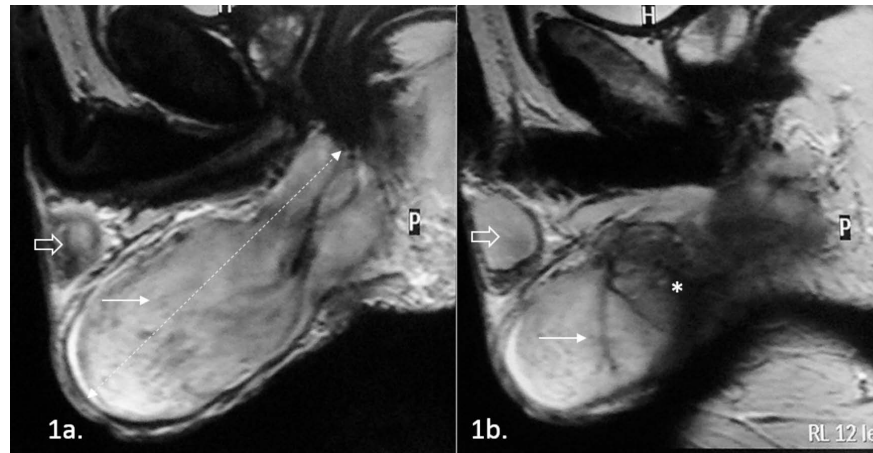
Magnetic resonance imaging of the scrotum. The T2-TSE images, in sagittal plain, show the extension of the mass (arrow) from the base of the corpus cavernosum posteriorly, to the posterior-inferior edge of the left testicle (open arrow). The mass demonstrates a heterogeneously high T2 signal intensity, surrounded by a thin low signal intensity capsule and is clearly separated from the ipsilateral testicle (open arrow). Although the capsule seems intact, the mass is not clearly distinguished from the posterior scrotal structures (*).
